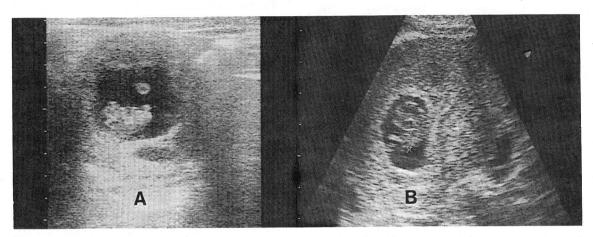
A. Ultrasonographic findings of transverse section of the uterus, with normal pregnancy outcome. Fetal crown-rump length was 20mm and the mean gestational sac was 33mm. (G-SAC>0.5 CRL+15)
